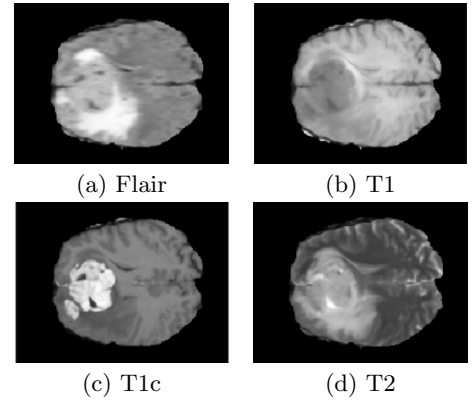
Example of MRI multi-modal images in BRATS dataset: (a) Flair; (b) T1; (c) T1c; (d) T2.
